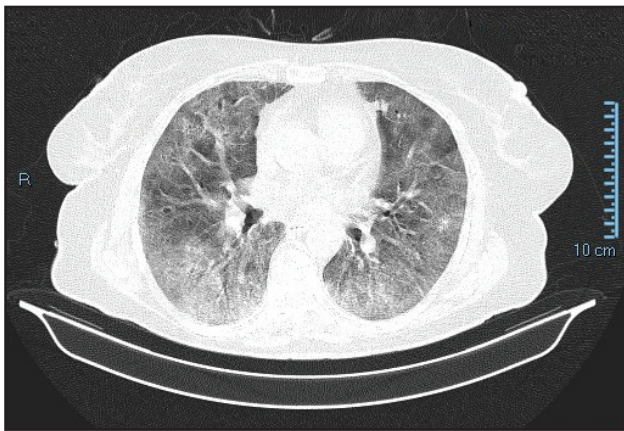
Pulmonary CT scan native in the 15th day of hospital admission compared to the investigation performed in the 7th day of hospital admission, highlights pulmonary lesions of SARS-CoV2 type in discrete remission in left pulmonary area.
